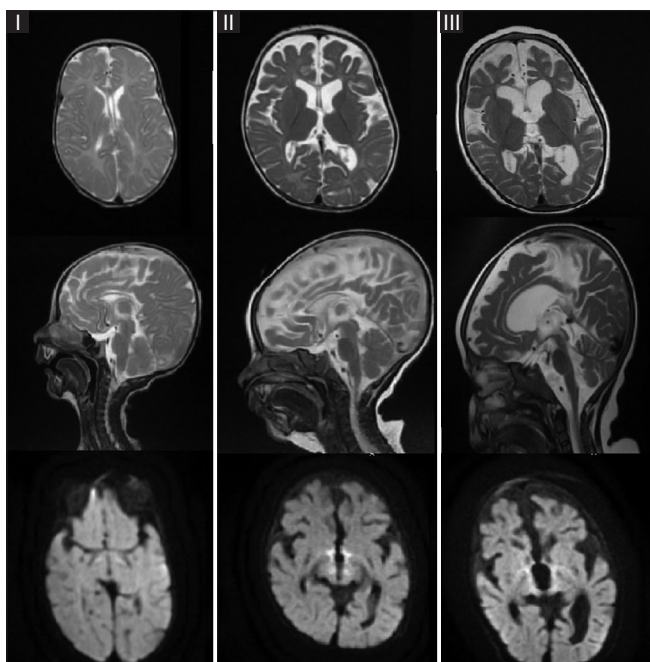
Serial T2-FSE and isotropic DWI images at 2 months (I), at 5 months (II), and 16 months (III). Initial MR imaging showed a thinned corpus callosum with no diffusion abnormality. Follow-up MR imaging showed a cerebral atrophy. The occipital cortex, basal ganglia and cerebellum appear spared. Bilaterally significant restricted diffusion was seen in the medial inferior thalami and extending into the central tegmental tracts. Final MR imaging showed a marked cerebral atrophy, mild cerebellar and brainstem atrophy and diffusion abnormalities remains
